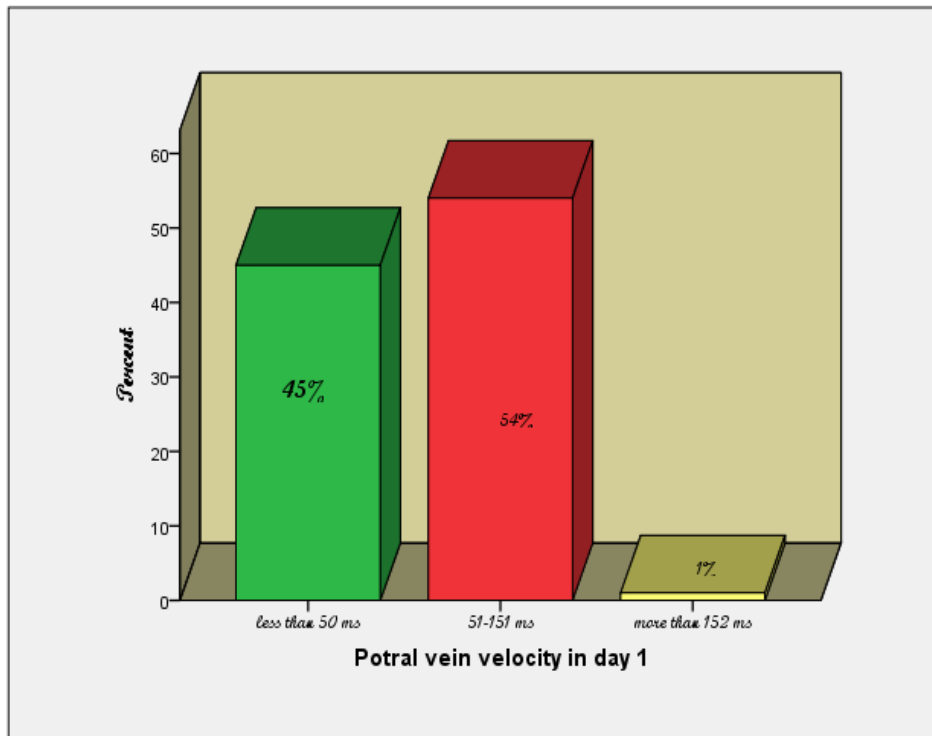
Frequency distribution of spectral Doppler for portal vein in day 1
